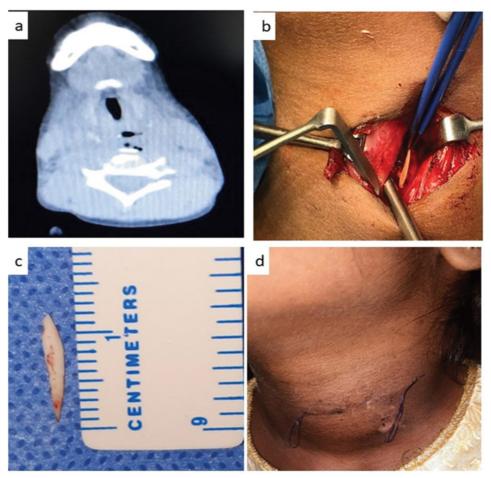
Nine years old female child with history of chicken bone ingestion who presented with dysphagia and odynophagia. (a) Coronal section of CT of neck showing well defined RPA with air foci within and hyperdense foci measuring 1* 0.4 cm with 2.5mm thickness is noted within the collection at C5 vertebra; (b) Intra operative picture showing lateral neck approach retrieving the foreign body; (c) foreign body removed; (d) Post operative scar picture.
